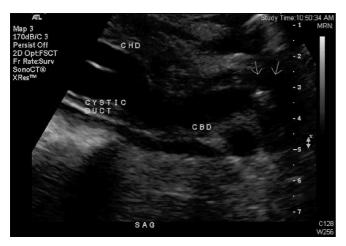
Choledocholithiasis on endoscopic ultrasound. This endoscopic ultrasound image shows a gallstone (arrows) in the common bile duct. The common hepatic duct (CHD) and cystic duct are seen to the left. Note that the CBD diameter is roughly 10 mm.
